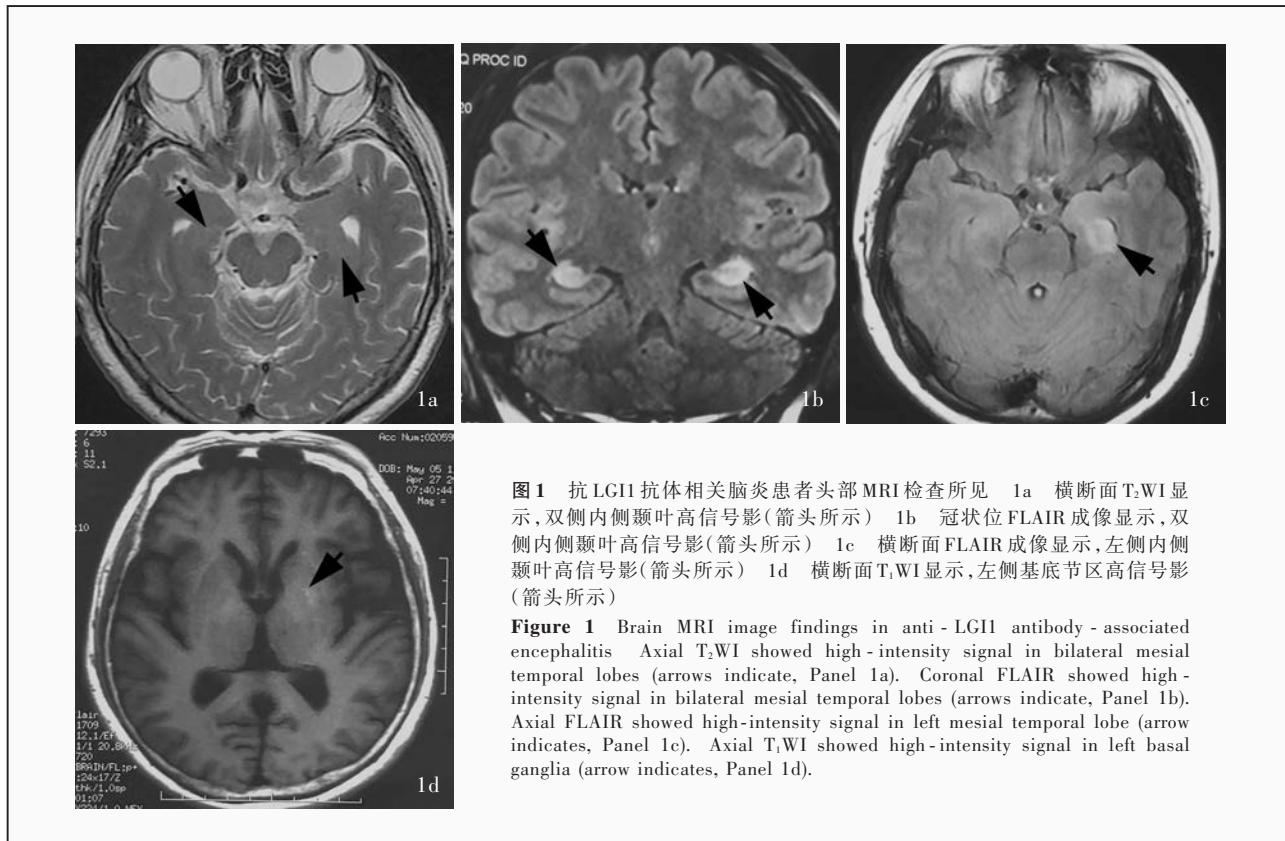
抗 LGI1 抗体相关脑炎患者头部 MRI 检查所见 1a 横断面 T₂WI 显示, 双侧内侧颞叶高信号影(箭头所示) 1b 冠状面 FLAIR 成像显示, 双侧内侧颞叶高信号影(箭头所示) 1c 横断面 FLAIR 成像显示, 左侧内侧颞叶高信号影(箭头所示) 1d 横断面 T₁WI 显示, 左侧基底节区高信号影(箭头所示)
